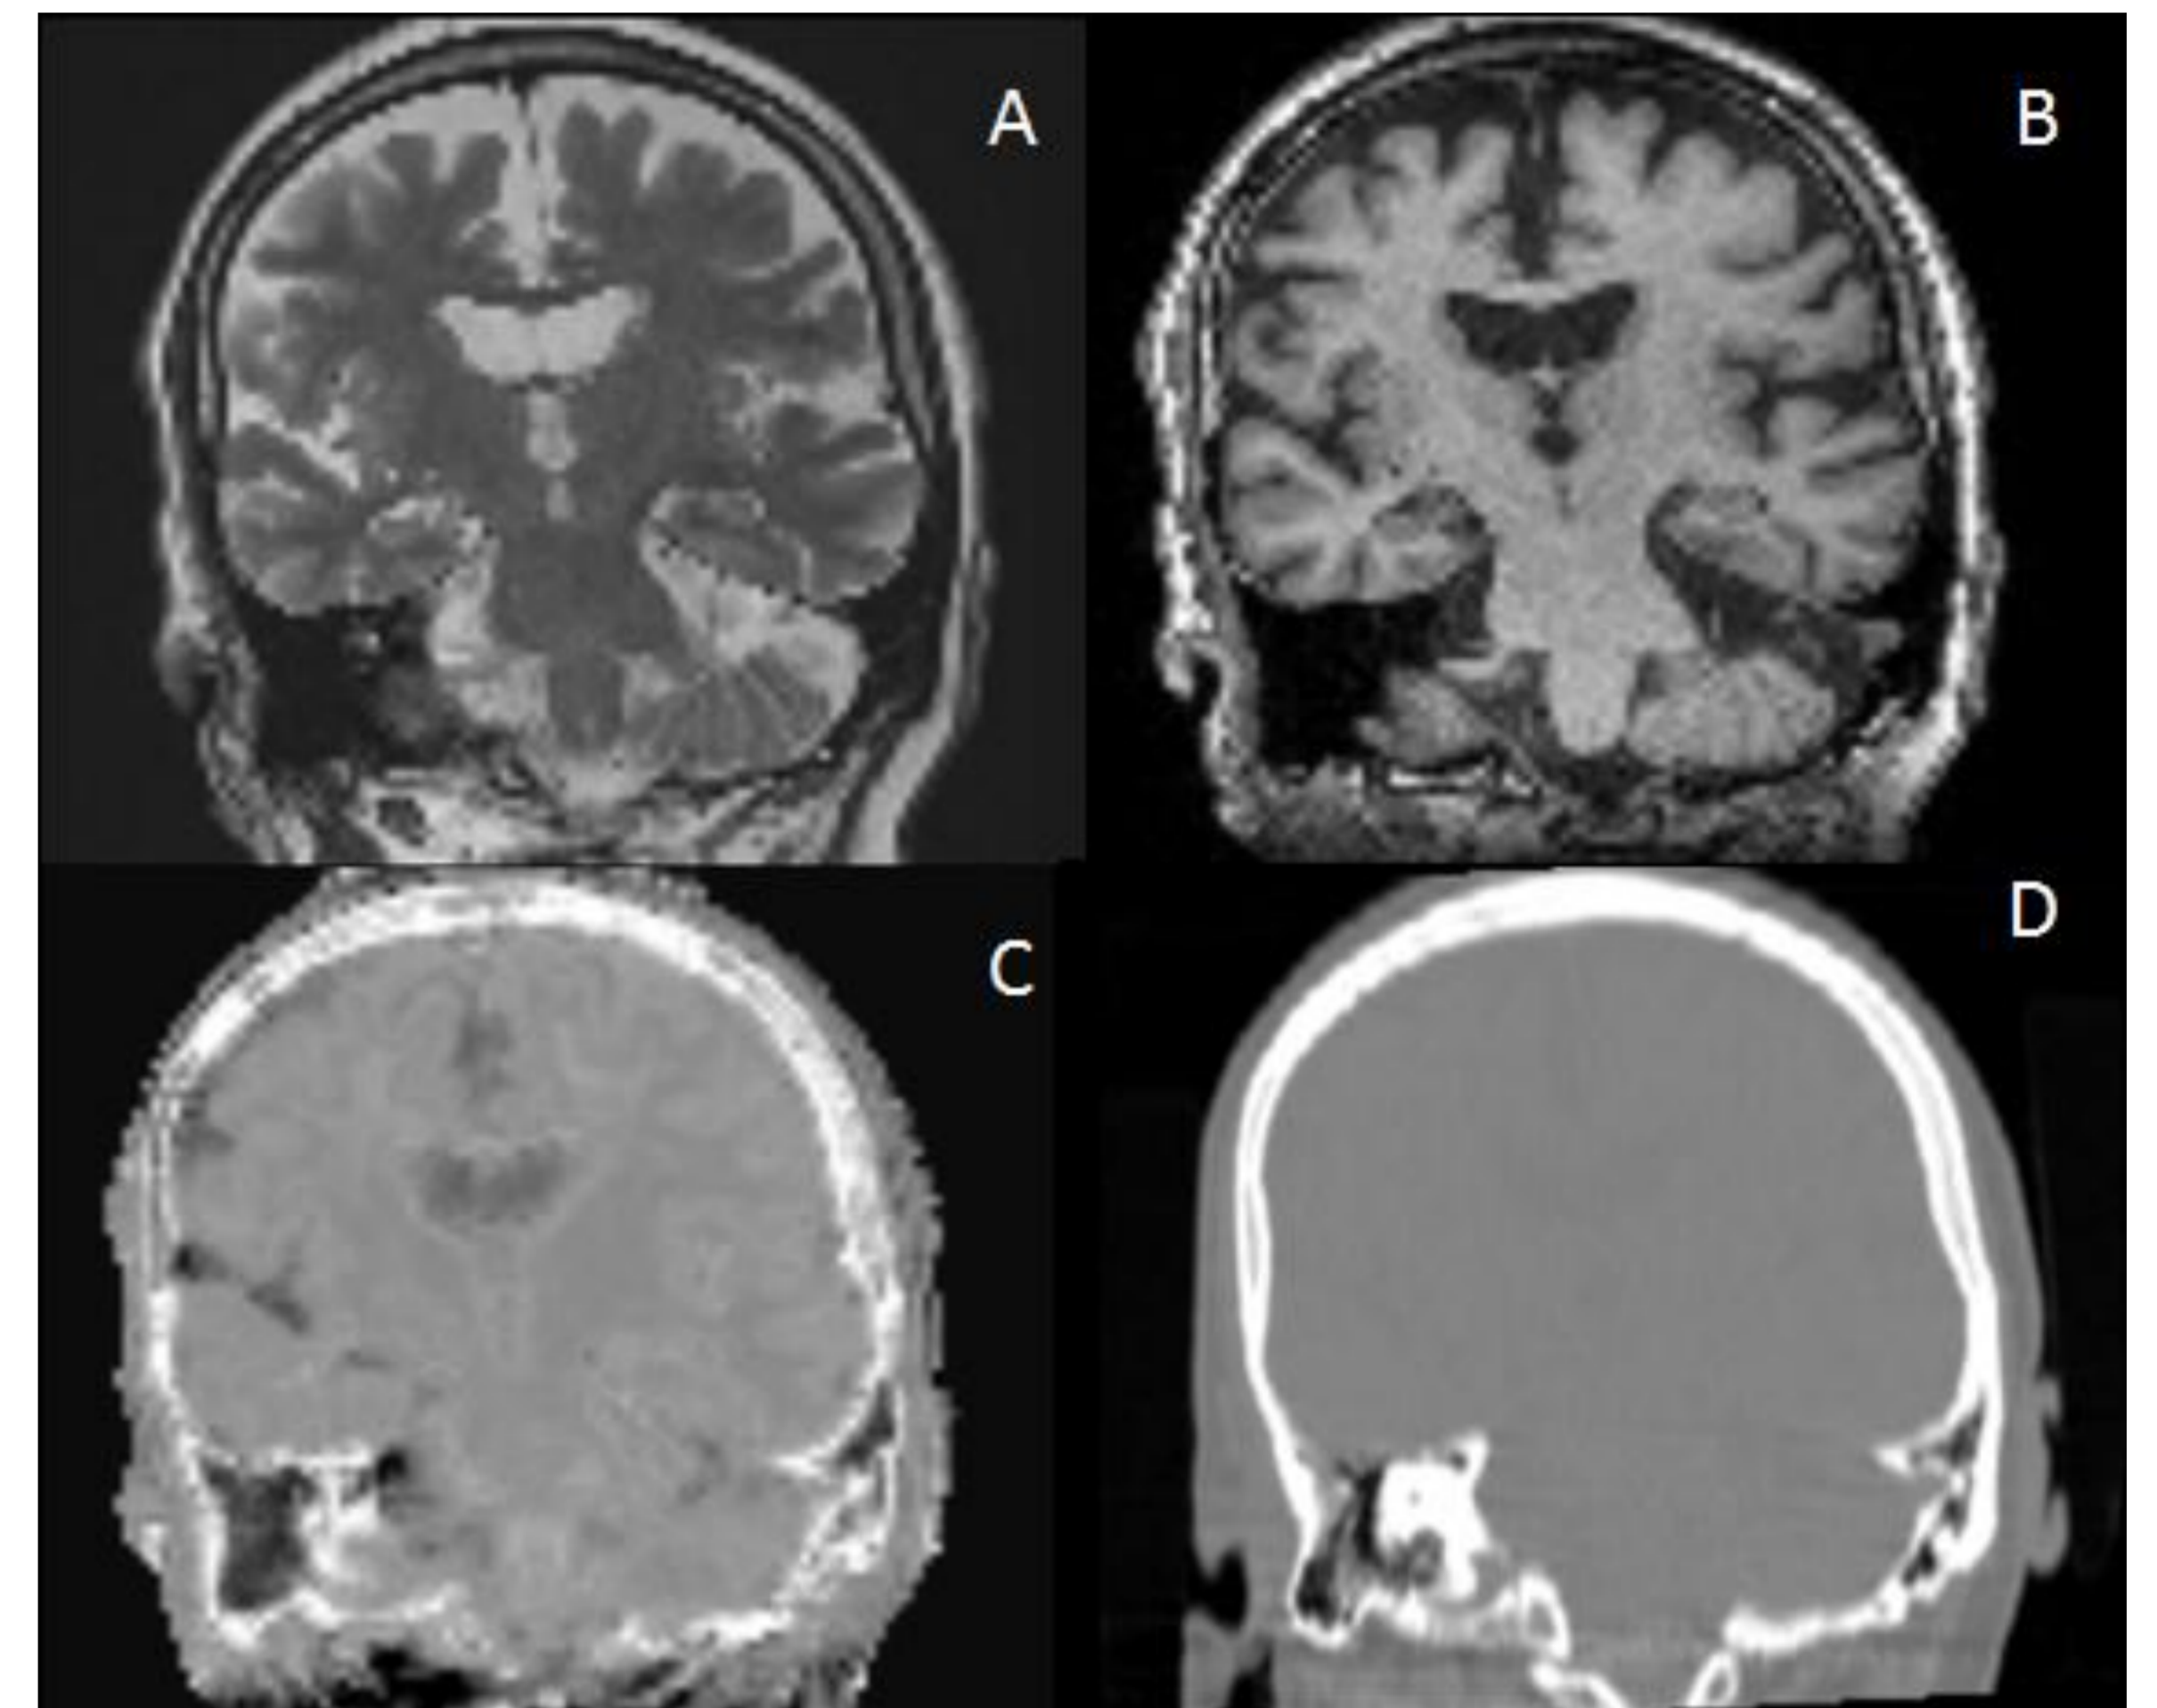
(A) T2-TSE, (B) T1-MPRAGE, (C) MR derived CT, (D) Patient CT.
